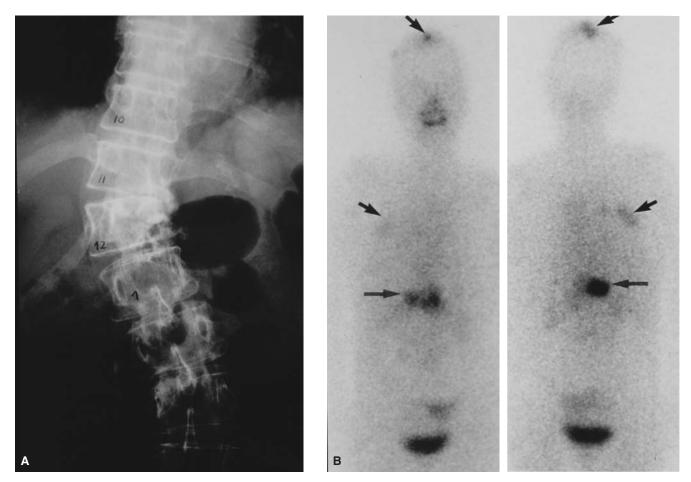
Papillary thyroid carcinoma with symptomatic bone metastases. *A*, Plain radiograph of the thoracolumbar spine showing partial destruction of T11 and T12 vertebral bodies, resulting in scoliosis. *B*, Total-body scan performed 72 hours after a high-dose (200 mCi) radioactive iodine (¹³¹I) therapy showing intense ¹³¹I uptake in vertebral bodies (*arrow*) and lesser degrees of ¹³¹I uptake in the ribs and the skull (*shorter arrows*), indicating multiple sites of bony metastases. Unlike the case shown in Figure 2–15, this patient is unlikely to achieve complete treatment response. *B*, (1) anterior view, (2) posterior view. Courtesy of C. H. Goh, MD, Department of Nuclear Medicine, Singapore General Hospital, Singapore.
